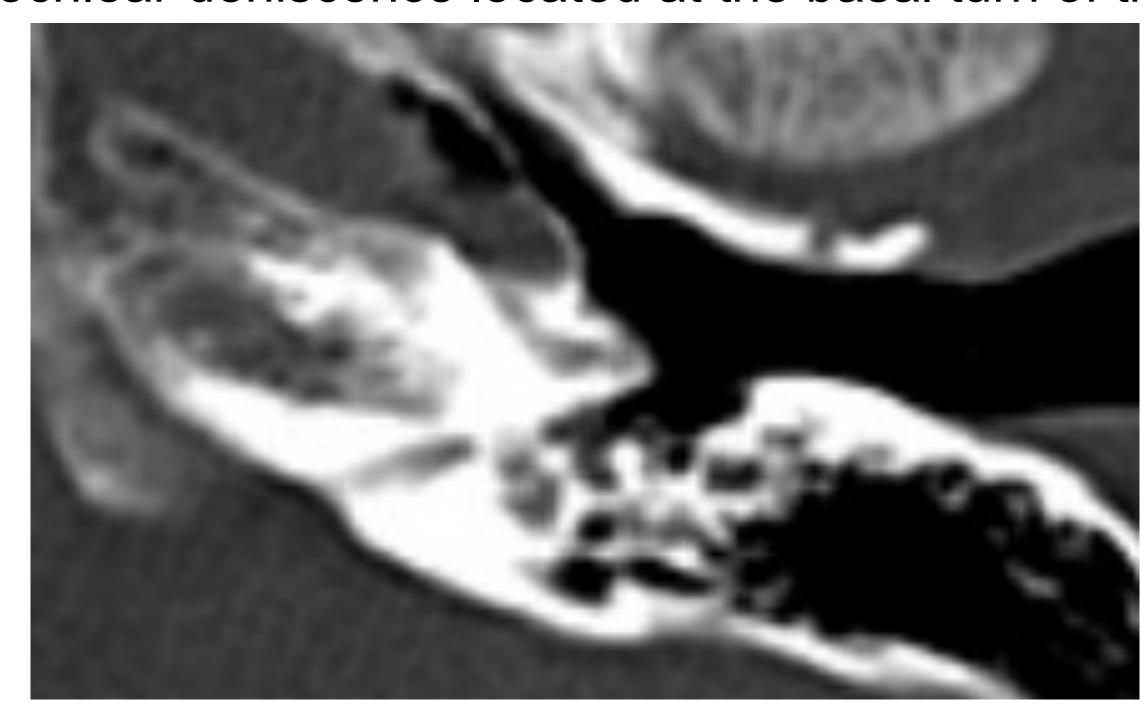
CTA Coronal Left Cochlea Lateralization of the left carotid artery
